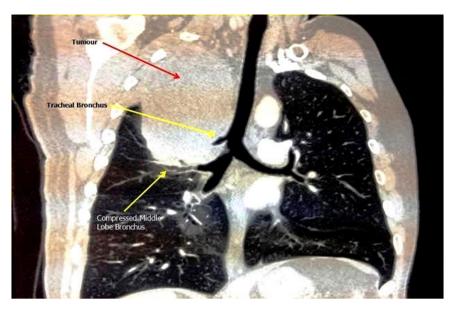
CT-chest showing a large right upper lobe soft tissue mass arising from a tracheal bronchus compressing the middle lobe bronchus and mediastinum.
